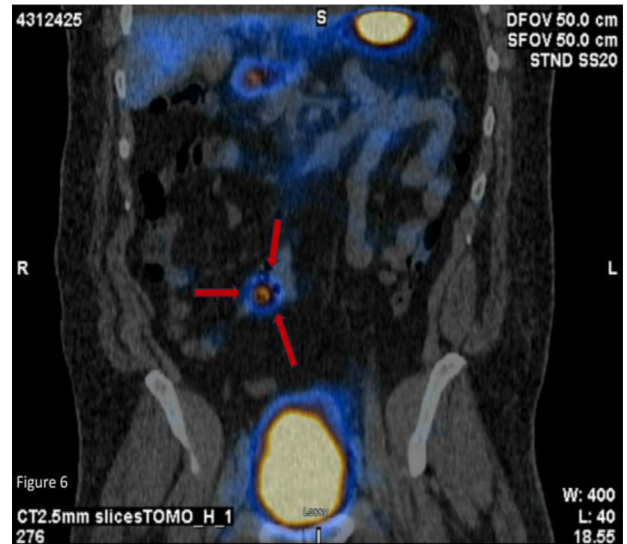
SPECT-CT was obtained (representative coronal slice), localizing the area of abnormal pertechnetate uptake to the blind-ending structure described on CT, confirming the diagnosis of a MD.
